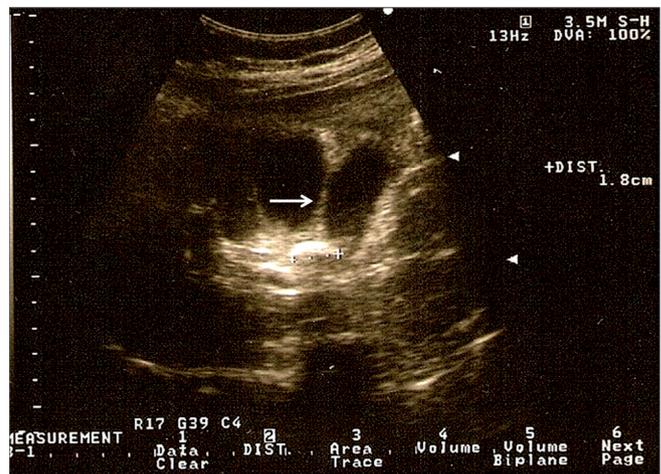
Preoperative ultrasound image of the right upper abdominal quadrant. Note the septum (white arrow) that divides the gallbladder in two ovoid and anechoic structures, and a stone with a diameter of 1,8 cm.
